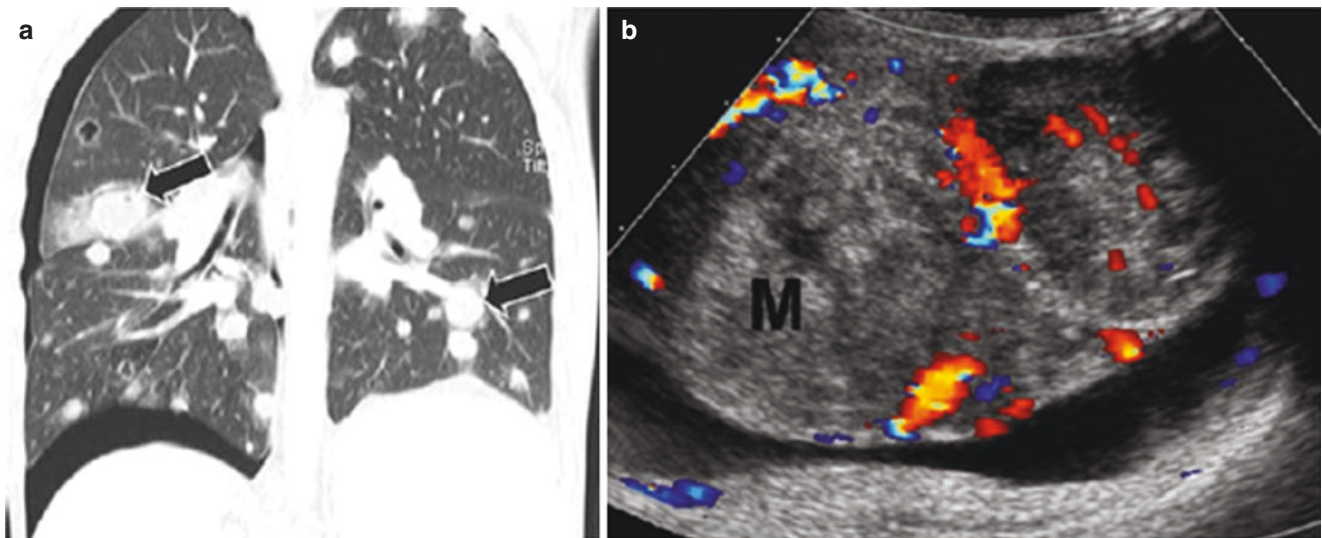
A 12-year-old boy who presented with shortness of breath and enlarged scrotum on physical examination. Surgical pathology was consistent with testicular neoplasm. (a) Coronal lung window CT
